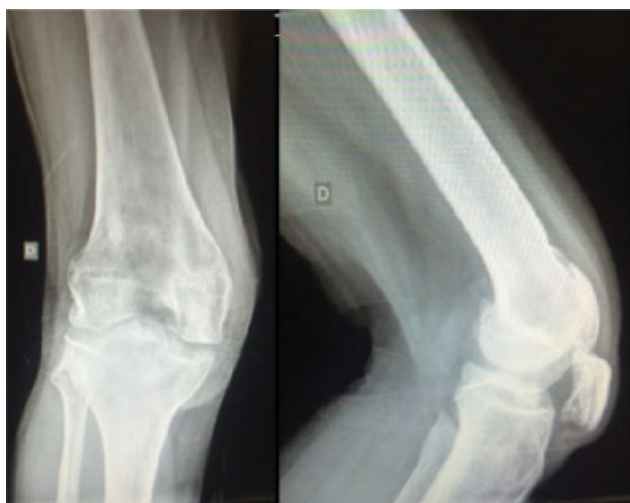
Initial radiographs of the right knee.
